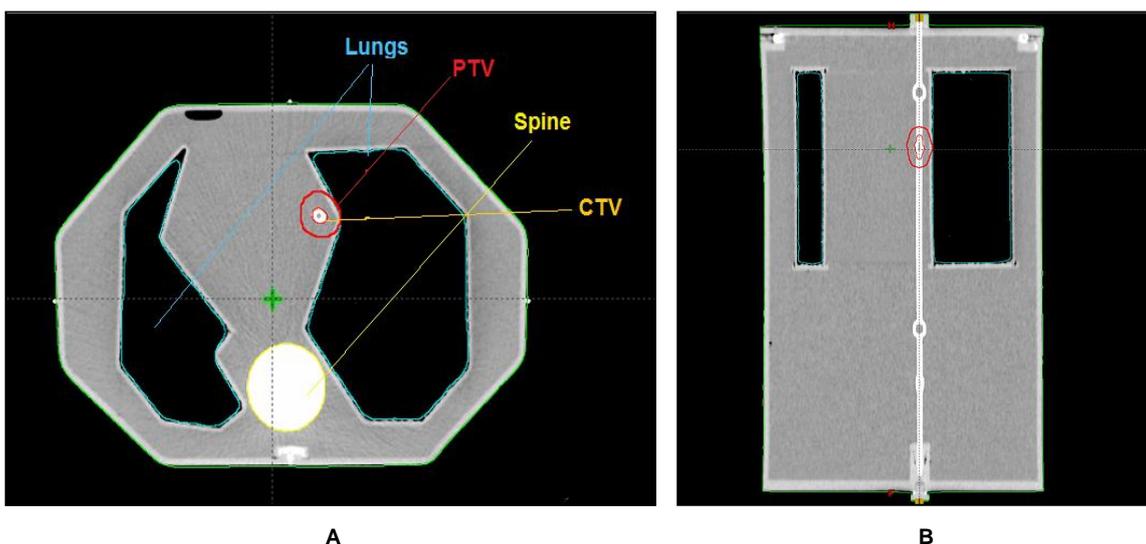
A: Axial CT volumes; B: Sagittal CT volumes.
